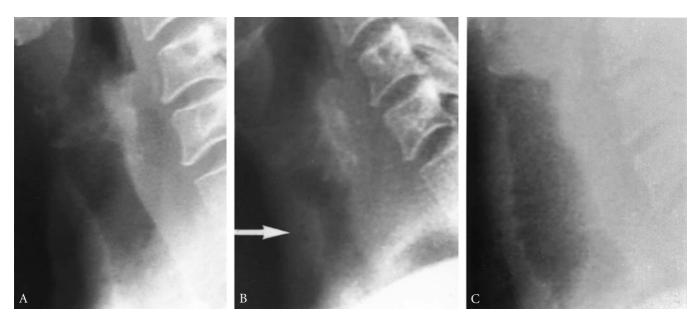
Localized tracheomalacia in a 16-year-old male, resulting from prolonged ventilation for several months, via a tracheostomy, subsequent to severe head injury, coma, and multiple complications. In addition to a distal 2.5 cm long circumferential stenosis due to cuff injury 2 cm below a stoma, he had a 2 to 3 cm segment of malacia of the anterior tracheal wall above the stoma from prolonged pressure by the tracheostomy tube during ventilation. A, Lateral neck roentgenogram shows an apparently normal upper tracheal air column with the patient at rest. Stenosis is distal and not visualized in this roentgenogram. Calcification in larynx is visible superiorly. B, Forced inspiration shows collapse of the soft anterior tracheal wall (arrow). C, On expiration, the anterior tracheal wall is distended. After circumferential resection of the distal stenosis, obstruction was apparent due to the malacic trachea. Through a separate small incision, a perforated polypropylene ring was inserted to encircle and support the soft segment. Excision of both lesions in continuity would have been too long to allow a safe anastomosis. Two separate excisions would have endangered the blood supply of the short intervening segment of the trachea. Two-stage resection would also have been possible. This patient's airway remains excellent 32 years later.
